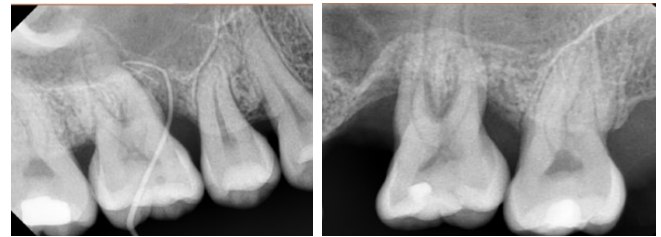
Intraoral periapical radiograph of upper right (left) and left (right) first molars
